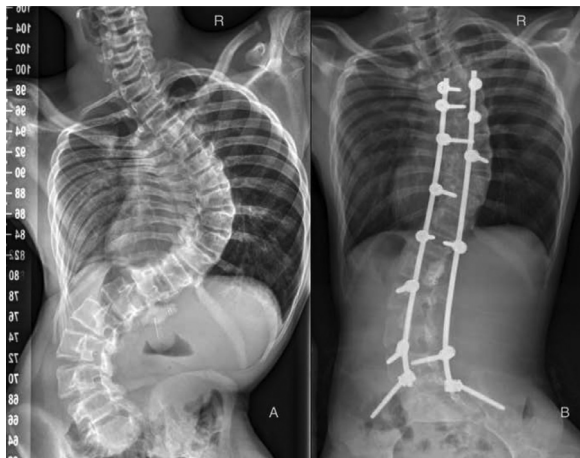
A: 15-year-old patient with a cerebral palsy related scoliosis. Preoperative whole spine radiograph with a double curved scoliotic deformity of 95° Cobb angle between Th12 and L5 and 105° between Th3 and Th12. Pelvic obliquity (Maloney) of 13°
